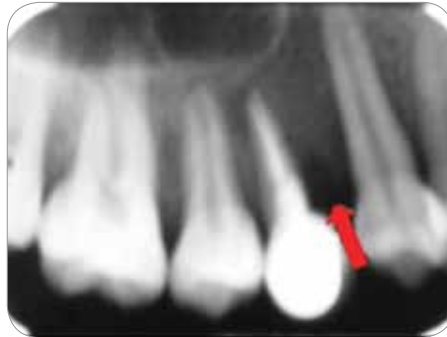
Intraoral periapical radiograph showing bone formation 10 months after surgery.
